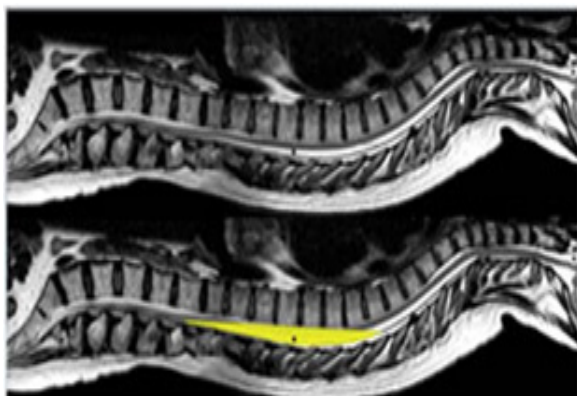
MRI of the Spinal Cord (demonstrates a relatively wide space at the thoracic level).²⁰
